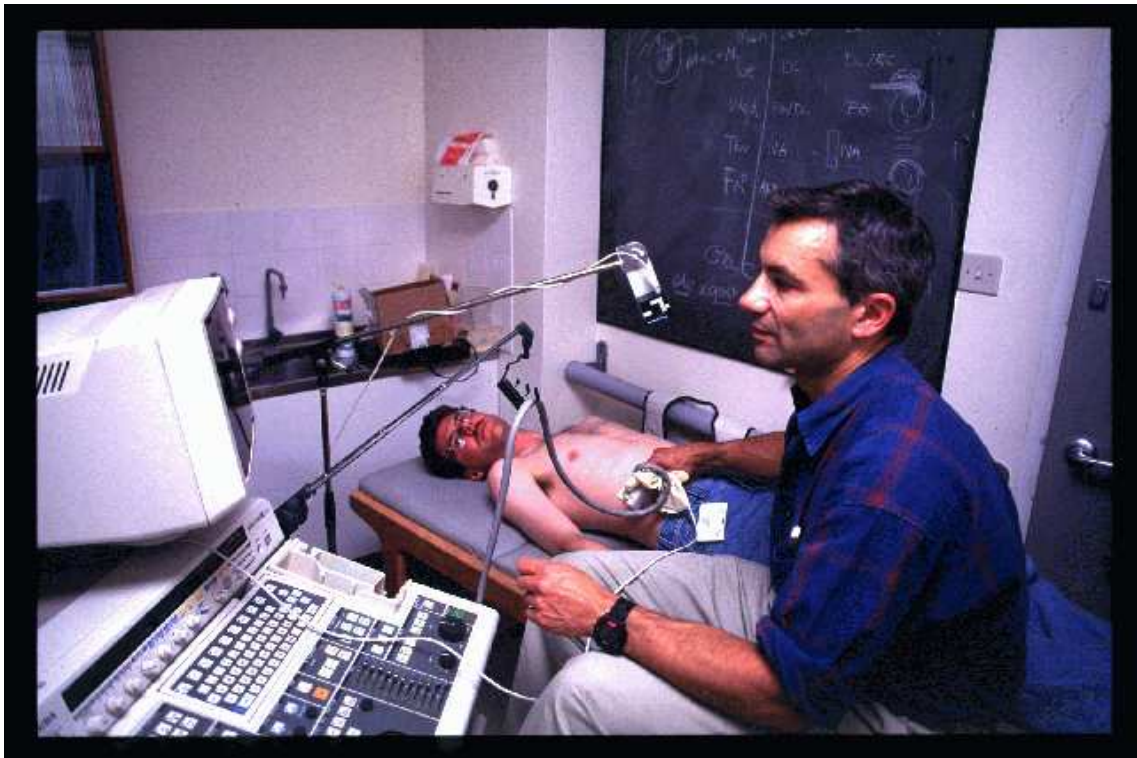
3D freehand ultrasound examination. The author is examined by Dr. Lol Berman in the Department of Radiology at Addenbrooke's Hospital.
